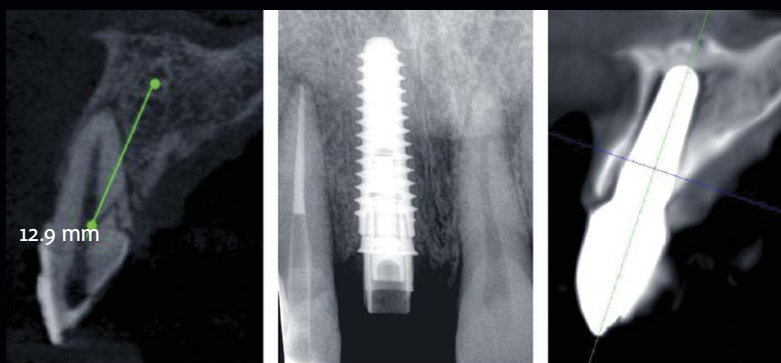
Intraoral radiograph of the provisional and CBCT control at 15 months. The shield is clearly visible, maintaining the cortical plate and tissue volume.
